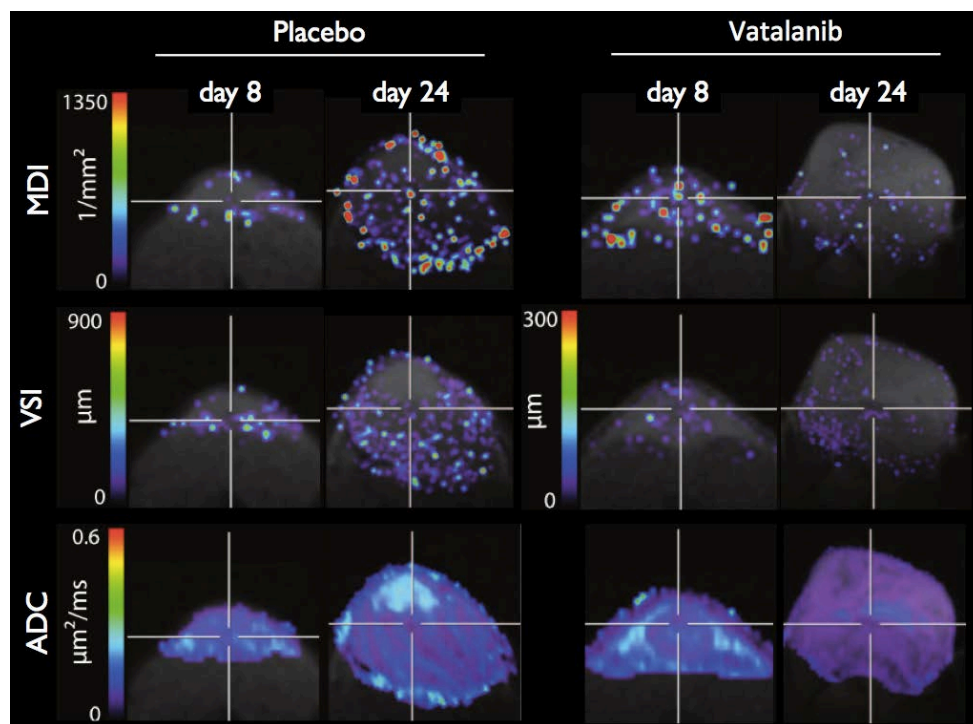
Multiparameter-imaging in MRI. Longitudinal investigations of vascular dynamics during tumor growth and antiangiogenic therapy. The effect of treatment with vatalanib on the tumor microvessel density index (MDI), tumor vessel size (VSI) and apparent diffusion coefficient (ADC) during tumor growth and treatment was investigated. *Figure adapted from (Ullrich et al. 2011).*
